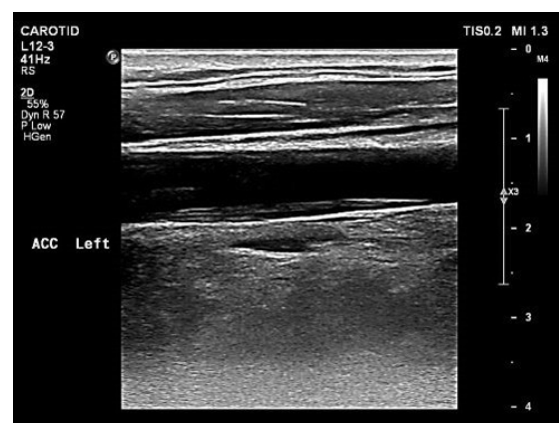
Ultrasound finding of multifocal stenosis of internal carotid artery
